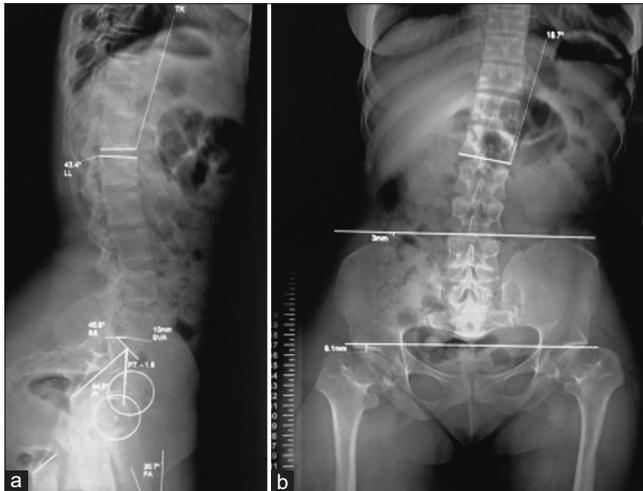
Total spine radiographs. (a) Posteroanterior radiograph shows large pedicle cortex outline, note the interpedicular distance progressively decrease from thoracic to the lumbar spine. Mild coronal imbalance is also seen. (b) Lateral views demonstrate short, large pedicles, and lumbar canal stenosis along with mild sagittal imbalance.
